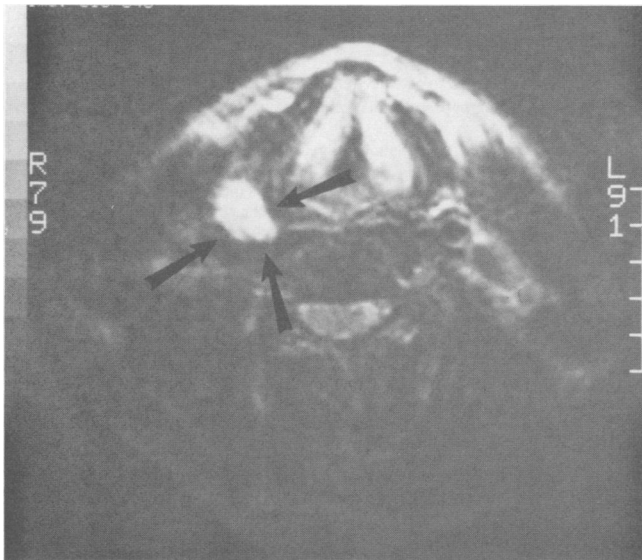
An axial T2-weighted (TE=80, TR=2,800) magnetic resonance image of the neck shows high signal emanating from a large parathyroid adenoma (arrows).
